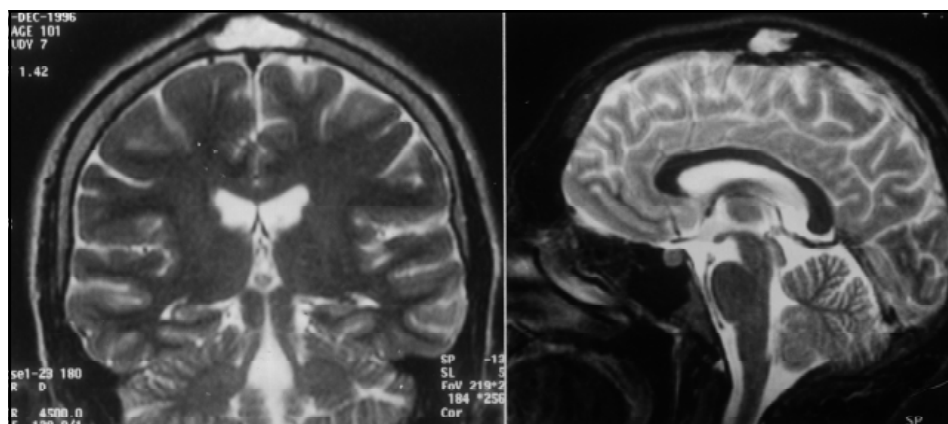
Patient's MRI: A: coronal T2-weighted section shows a biparietal lytic lesion without dural invasion ; B: sagittal T2-weighted section showing the same lesion.
